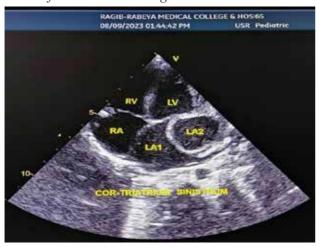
Apical four-chamber view in systole showing a membrane (Orange arrow) bisecting the left atrial cavity into LA-1 & LA-2. LA- Left atrium, RA- Right atrium, LV- Left ventricle & RV- Right ventricle.
